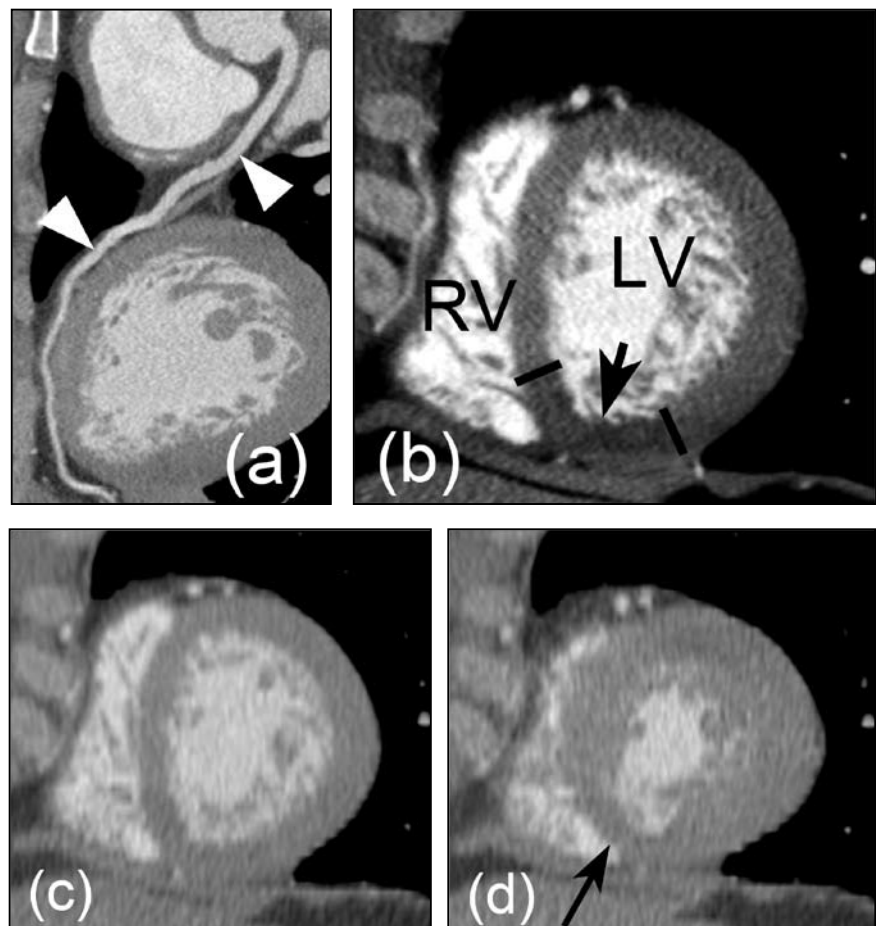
(a) Curved reconstructed image from the CCTA shows a normal LAD (arrowhead). (b) Short axis (SA) CT image shows a small focus of low density (relative darkness, arrow) in the inferior LV due to hypoperfusion. Small black bars delineate this segment. (c-d) End-diastolic and end-systolic phase SA CT images show lack of normal thickening of the underperfused segment (arrow).
